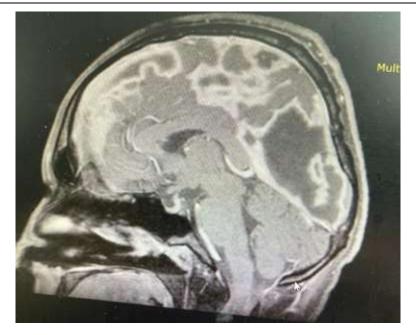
Cerebral MRI with Contrast Substance, Sagittal View, Multiple Parafalciform Abscesses
